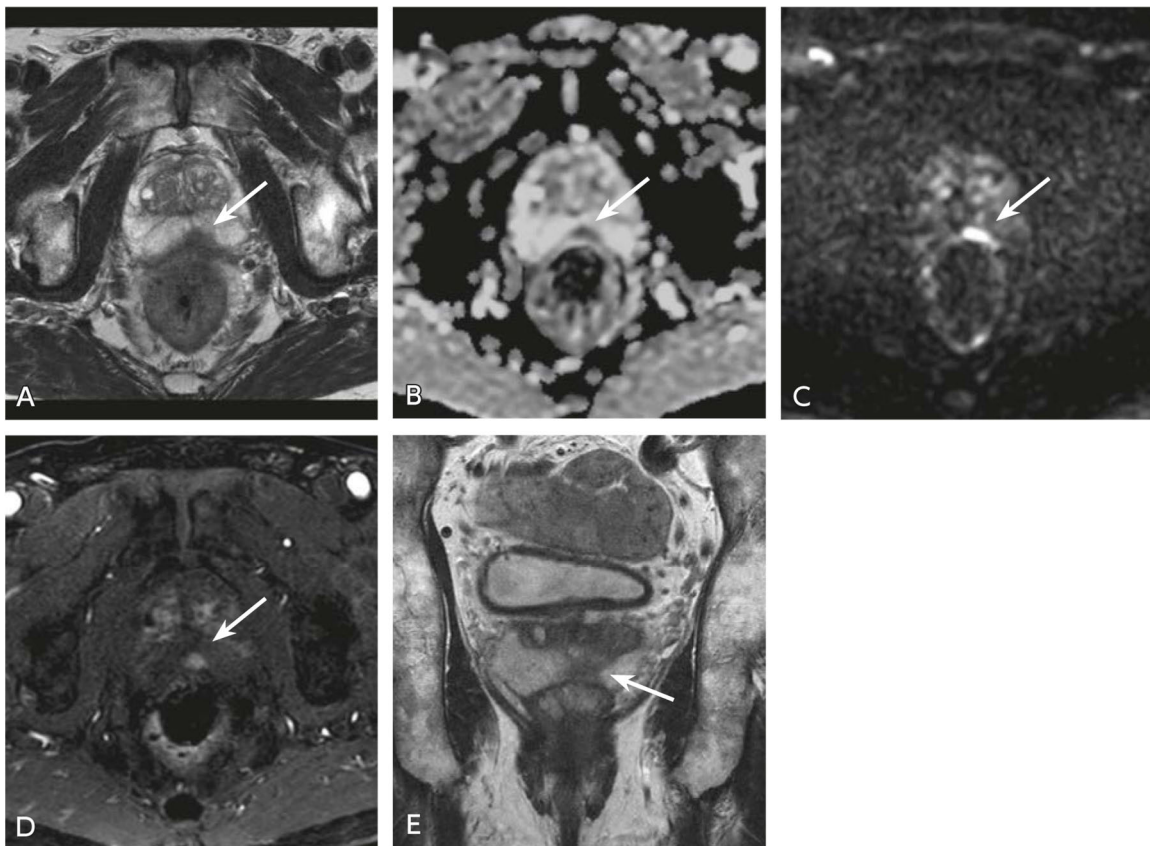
MRI of prostate cancer (T2a)
